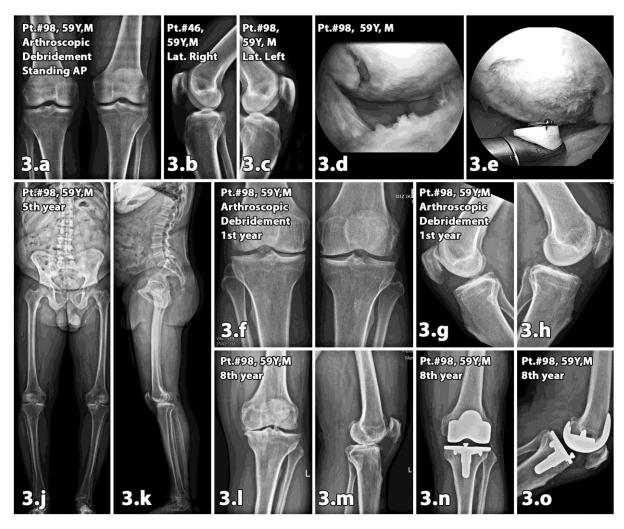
Pt.#98, This 59 years-old man had Kellgren-Lawrence Classification (KLC) grade-2 degeneration at first admission. (a) Standing Rosenberg AP x-rays of both knees prior to arthroscopic debridement, (b,c) lateral x-rays of both knees (d) image of cartilage degeneration on medial femoral condyl recording during arthroscopy, (e) debridement of degenerative cartilage with the radio-frequency during arthroscopy, (f-h) Standing AP and lateral x-rays of both knees at 1st year, (j,k) AP and lateral views of both knees at EOS graphies at 3rd year, (l,m) Standing AP and lateral x-rays of the left knee at 8th year, (n,o) AP and lateral x-rays following total knee arthroplasty at 8th year.
